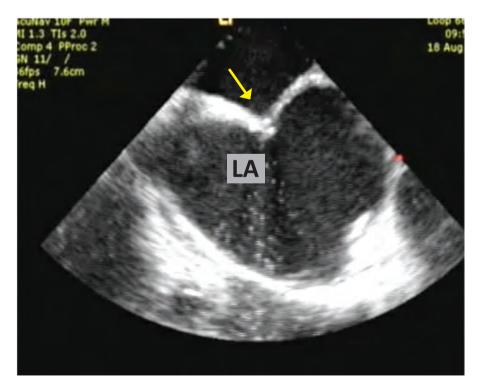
Intracardiac echocardiography (ICE) to visualize the septal puncture needle tenting (yellow arrow) a thick interatrial septum (compare the thickness of the interatrial septum to Figure 7)
